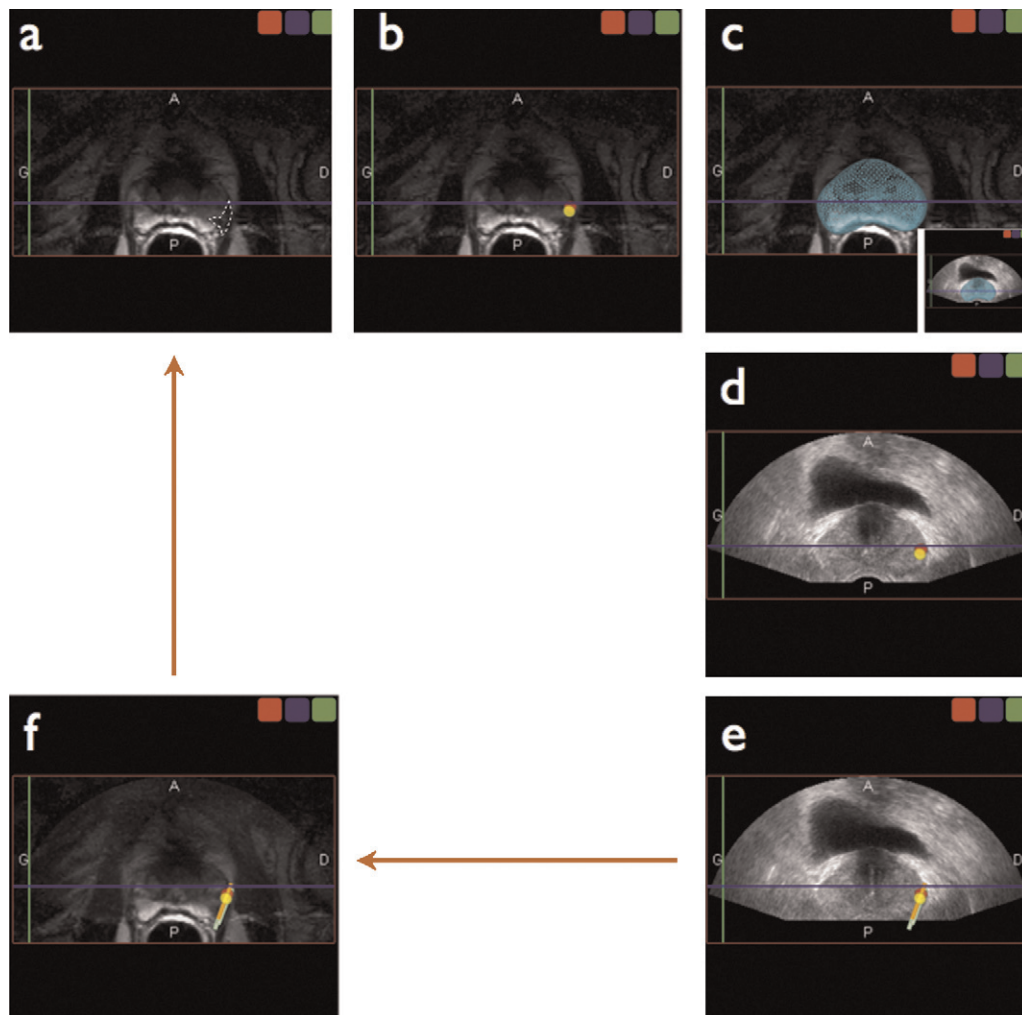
Postprocedure analysis of the European Society of Urogenital Radiology (ESUR) characteristics of multiparametric magnetic resonance imaging (mpMRI) Digital Imaging and Communications in Medicine archives; for clarity's sake, only the pictures pertaining to the target are presented. (a,b) Tagging of a suspicious focus in the right peripheral zone. (c,d) Transfer to the three-dimensional transrectal ultrasonography (3D TRUS) model by elastic surface registration ([c] T2-weighted magnetic resonance imaging; [inset] 3D TRUS). (e) Recording of the spatial location of the cores by repeating 3D TRUS with the needle left in place. (f) Reverse transfer to the mpMRI model. The actual ESUR characteristics of the site sampled by the cores was determined after the procedure by comparison with the initial mpMRI Digital Imaging and Communications in Medicine archives (a).
